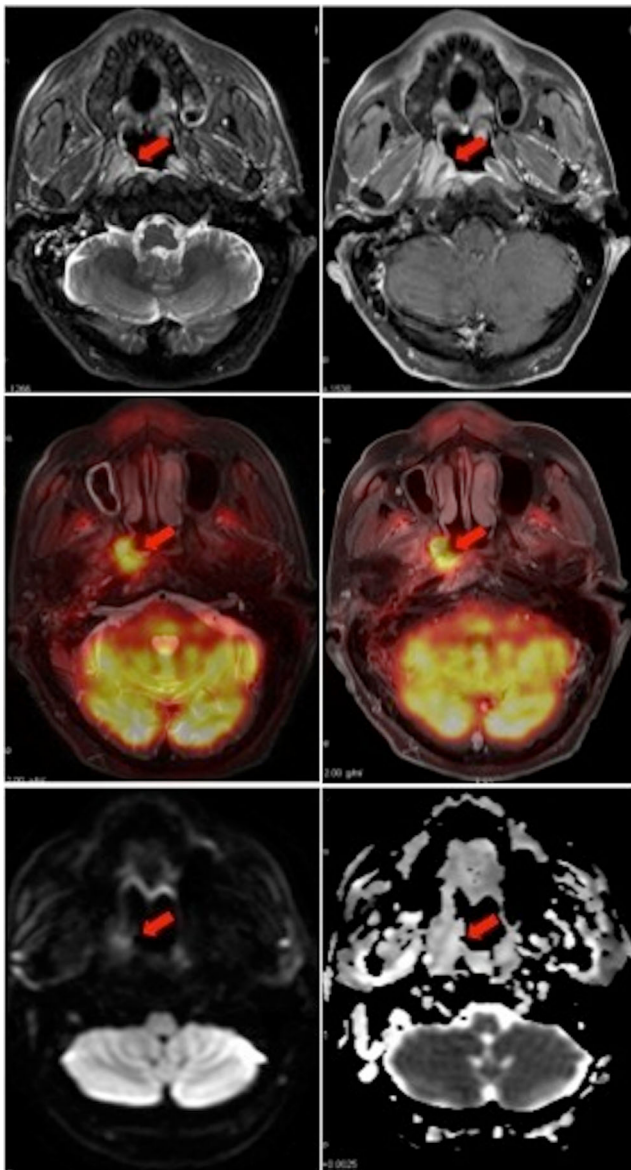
Thirty-five-year-old male with recurrence of a mesopharynx carcinoma in the right rosemuller fossa. PET/MRI accurately detected it, but DWI showed no restriction ($\text{ADC}_{\text{mean}} = 1.73 \times 10^{-3} \text{ mm}^2/\text{s}$)
